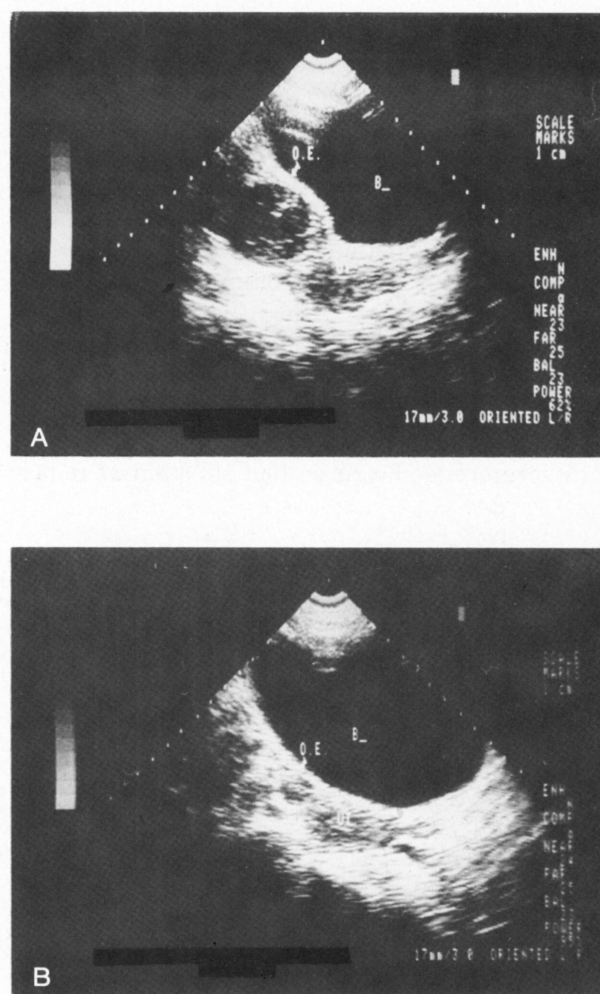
Thirty-one-year-old patient. Endometriotic cyst on the left ovary (OE) was diagnosed by laparoscopy. Real-time ultrasound image of cyst measuring 68.2 cm³ is shown before treatment (A) and after 6 months of gestrinone treatment by vaginal route, 2.5 mg three times weekly (B), when ovarian volume was restored to normal (11.6 cm³).
